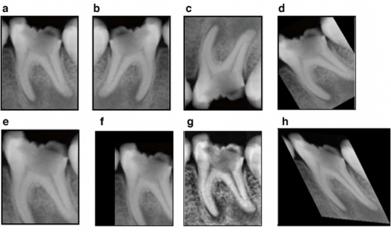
Data augmentation example of periapical X-ray. a. Original image, b, c. Flip, d. Rotation, e. Zoom. f, Translation, g. Contrast adjustment, h. Elastic deformation. Note that apical lesion is removed in d, e, and f, which can degrade performance of periapical lesion detection model (obtained from Heo et al).<sup>39</sup>
